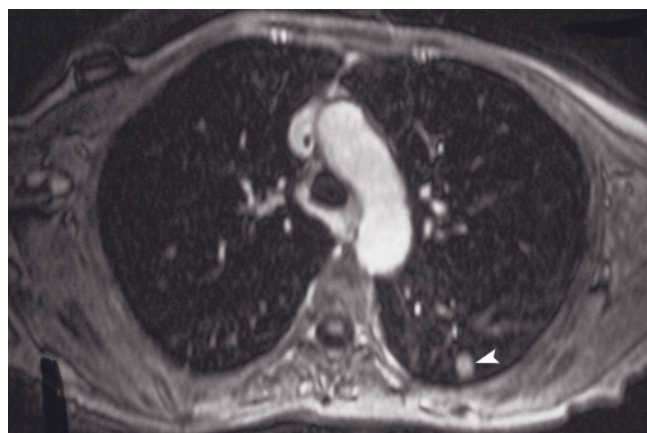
Pulmonary nodules. Small lung metastases in ten patients (*a–s*). T2-weighted ETSE (*e, g, m, n*), fat-suppressed ETSE (*a, c, k, l, o, u*), and short tau inversion recovery (*t*) and multiplanar gradient-echo images (*b, d, f, h, i, j, p–s, v, w*) in ten patients
